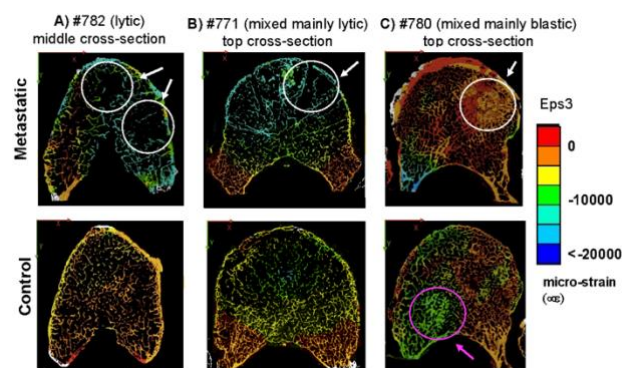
Comparison between the compressive strain field in a lytic (A), mixed with mainly lytic tissue (B) and mixed with mainly blastic tissue (C) metastatic vertebrae and their respective control vertebrae on μ CT cross-section. White circles indicate lytic and blastic lesions, pink circle indicates a region with denser trabecular pattern with an unexpected behaviour.
